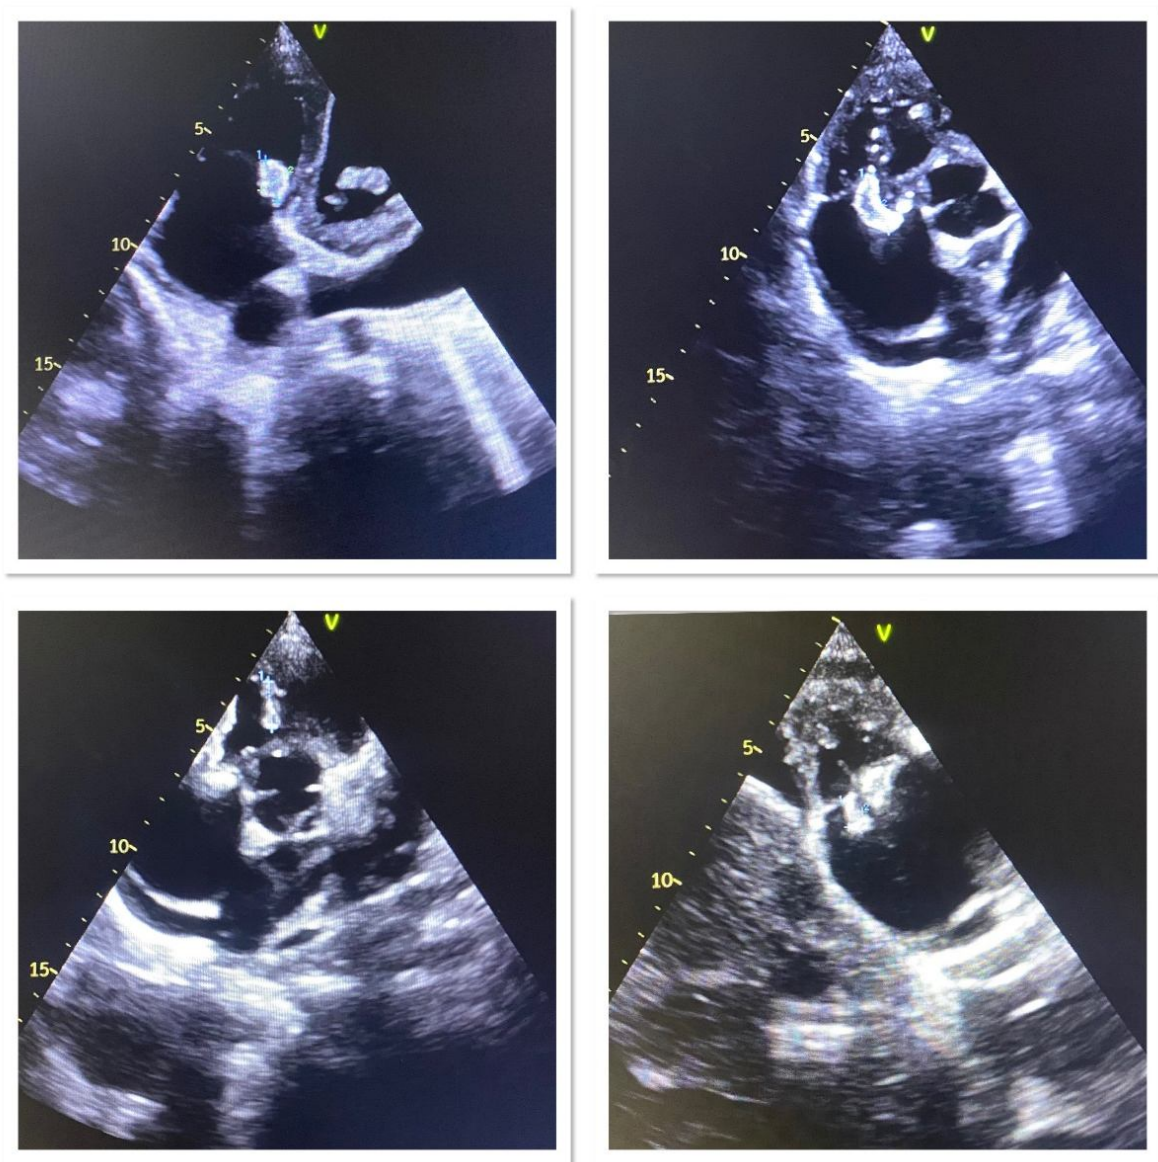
Transthoracic echocardiography showing vegetations, on the anterior leaflet, on the septal leaflet, and on the posterior leaflet and an other vegetation attached to the chordae tendineae.
